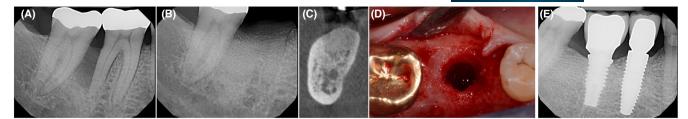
Implant site development with freeze-dried bone allograft (FDBA) and rhPDGF-BB. (A) Baseline. (B, C) The extraction socket was grafted with FDBA soaked with rhPDGF-BB. (C) Cone beam computed tomography scan taken after 4 months. (D) Re-entry and implant placement after 8 months. (E) Follow-up at 10 years.
